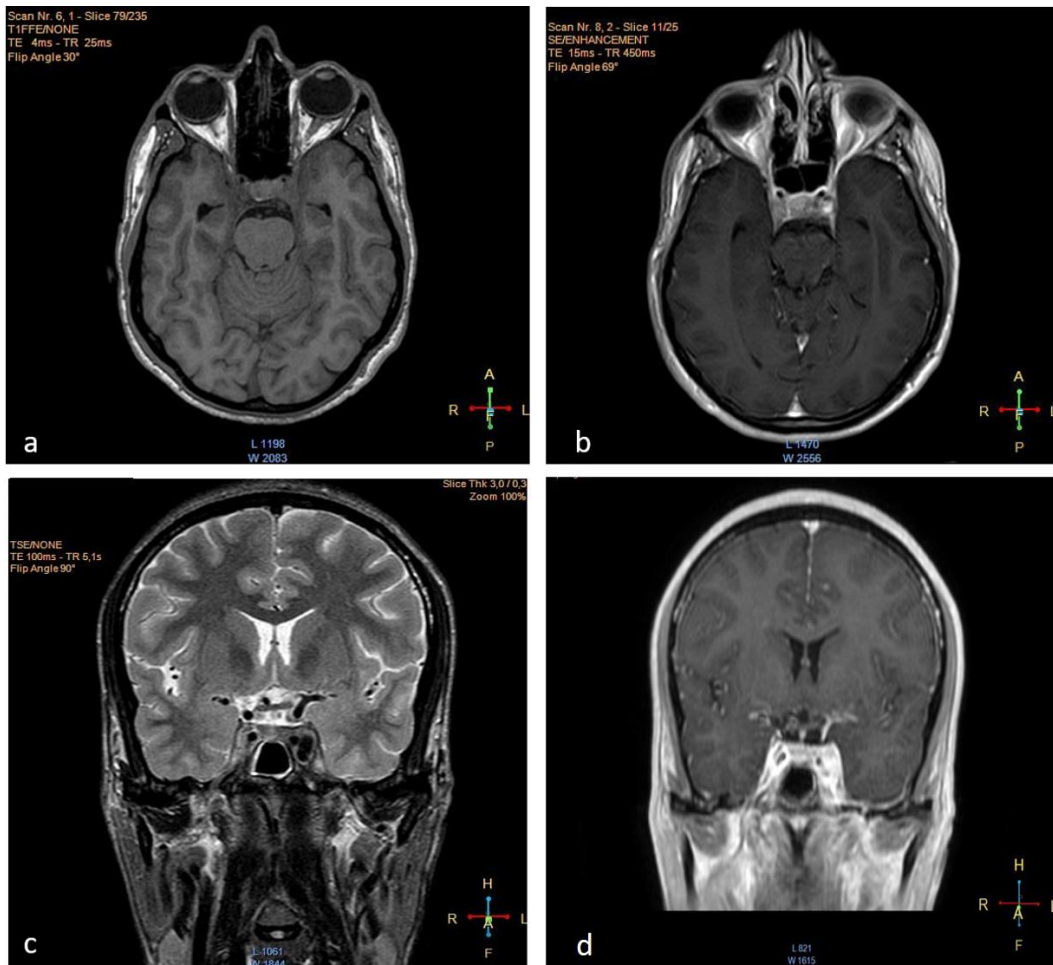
Pre (a) and post-contrast (b) T1 weighted MRI demonstrating inflammatory homogeneously enhancing changes within the left cavernous sinus and an internal carotid artery aneurysm about 8mm. Coronal T2 weighted (c) and coronal T1 weighted post-contrast (d)
